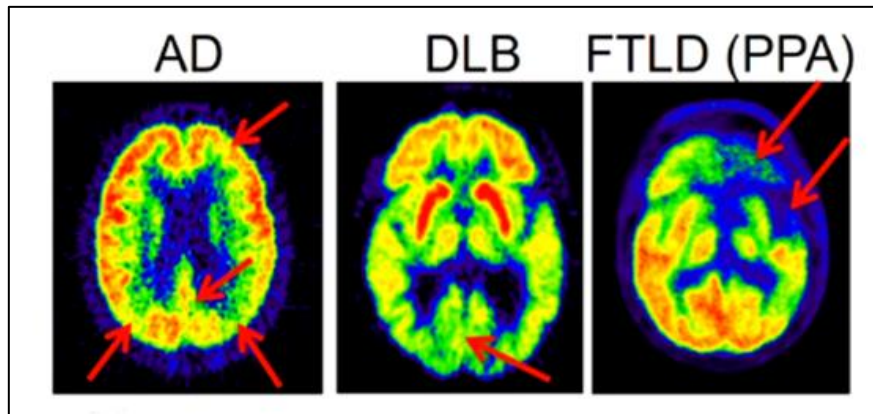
圖 十五、AD、DLB 及 FTLD 典型 FDG-PET 影像（作者摘錄）
